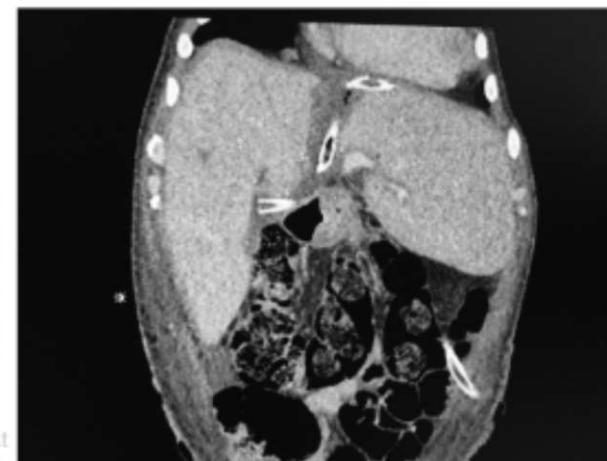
CT 15 days after the first procedure.
